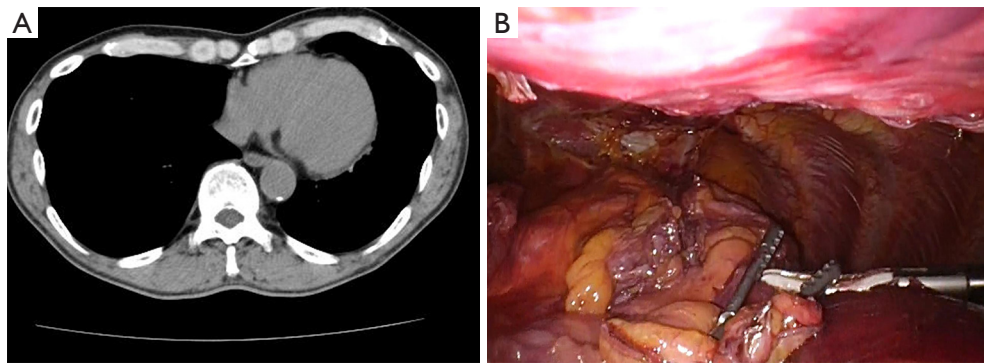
We performed a SUT. However, due to the patient's funnel chest, which obstructed full visualization of the thymus gland, we placed a 5 mm port in the left fifth intercostal space to complete the surgery. (A) Computed tomography image showing the patient's funnel chest; (B) sternal deformity obstructing an adequate operative view. SUT, subxiphoid uniportal thymectomy.
